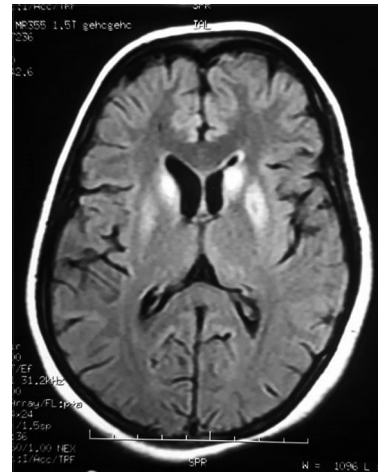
Cerebral MRI showing resolution of previous lesions after therapy and minimal persistence of FLAIR hyperintensities of the caudate head (magenta arrows) and globus pallidi (green arrows) and normal-appearing periaqueductal gray mater and dorsomedial thalami
